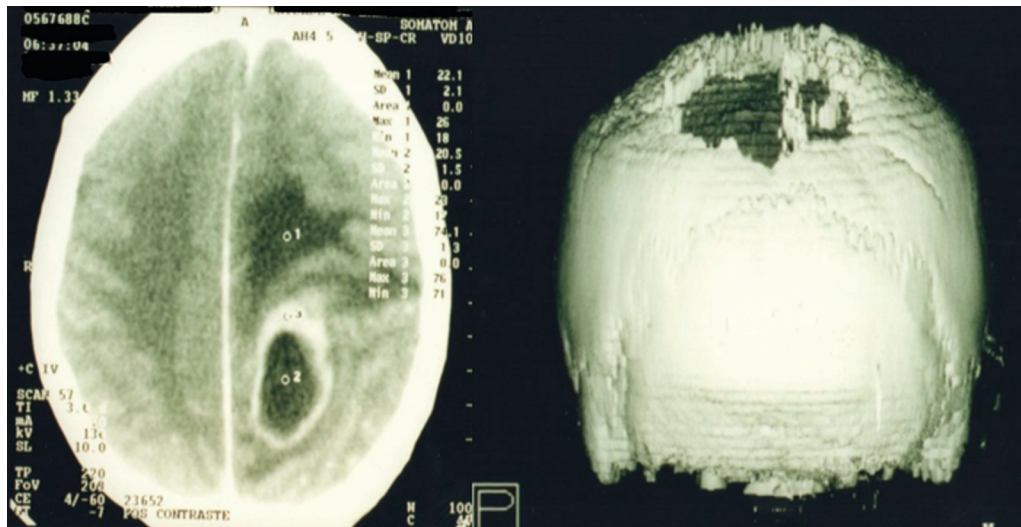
Computed tomography (CT) of the skull – hypodense, extra-axial lesion located in the left cerebral hemisphere and three dimensional reconstruction demonstrated extensive frontoparietal bone destruction.
